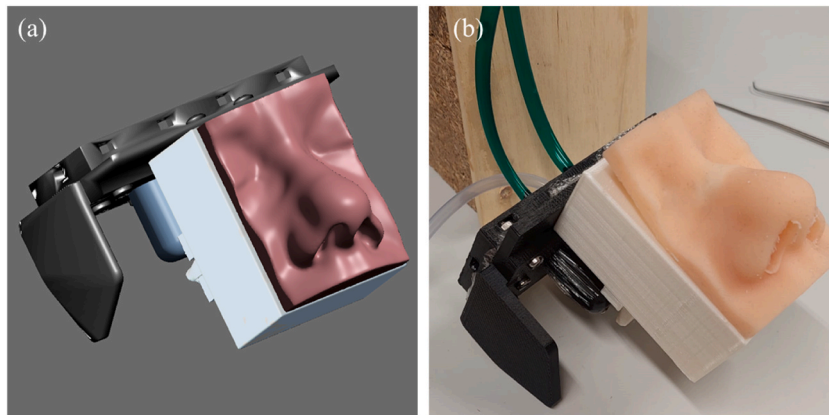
The CT-based training model. An interior view of the model shows the positioning of the turbinates and the nasal septum modules within the frame module (a). Overview of the assembled training model (b and c).
